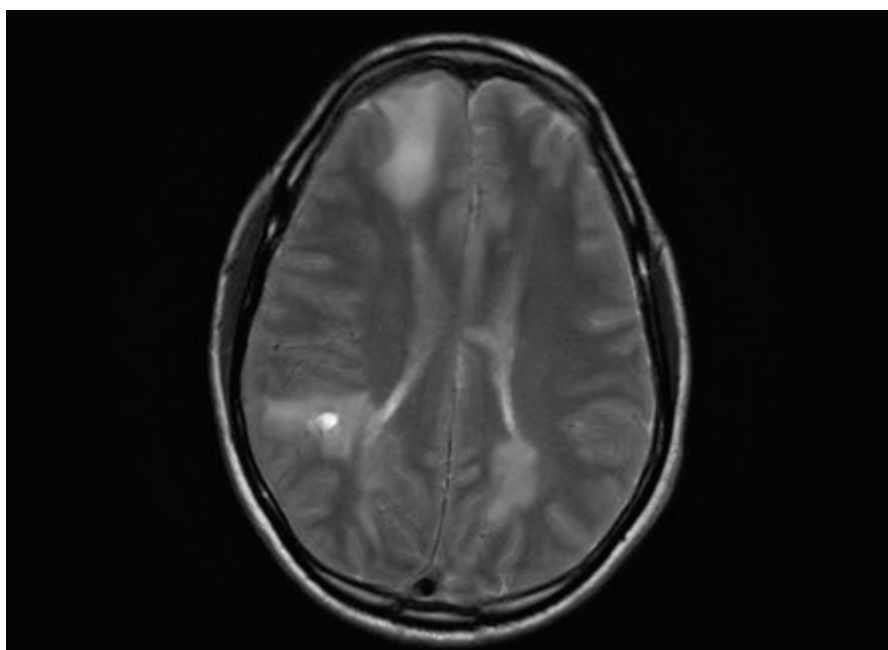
Axial T2 weighted MRI (27 year-old man with classical ataxia telangiectasia), showing bi-bilateral areas of white matter high signal with a cyst-like lesion.
